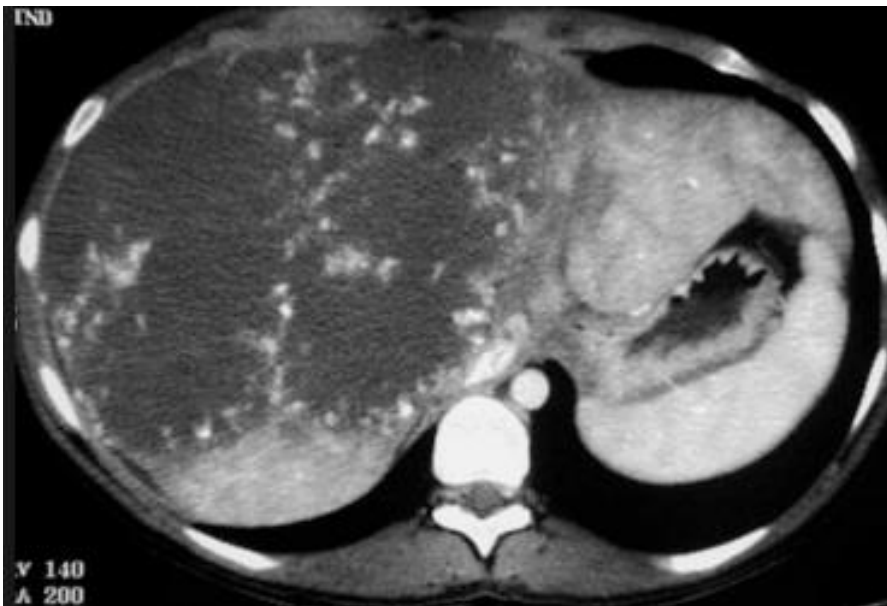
CT scan showing right liver hemangioma
